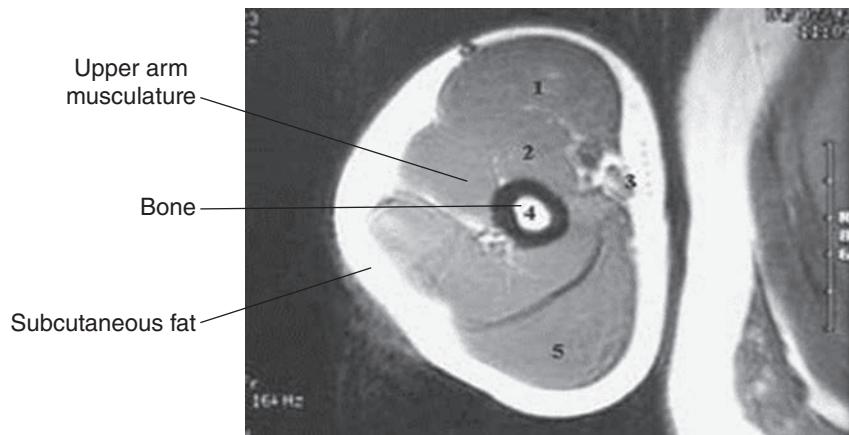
A cross section of the upper arm musculature (gray areas) of a trained young woman using magnetic resonance imaging (MRI). The subcutaneous fat (outer white area) decreases with strength training and proper nutritional programming allowing more definition of the upper arm musculature.
